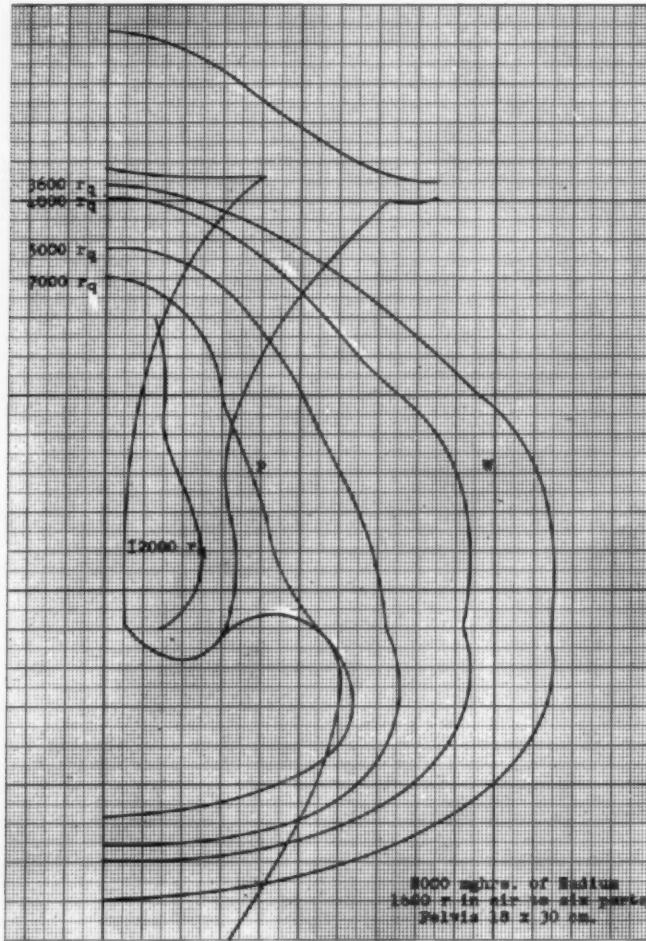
Isodose curves in the coronal plane of the pelvis for the combined treatment with radium and x-ray. Paracervical dose calculated at point *P*, pelvic wall doses at point *W*.
